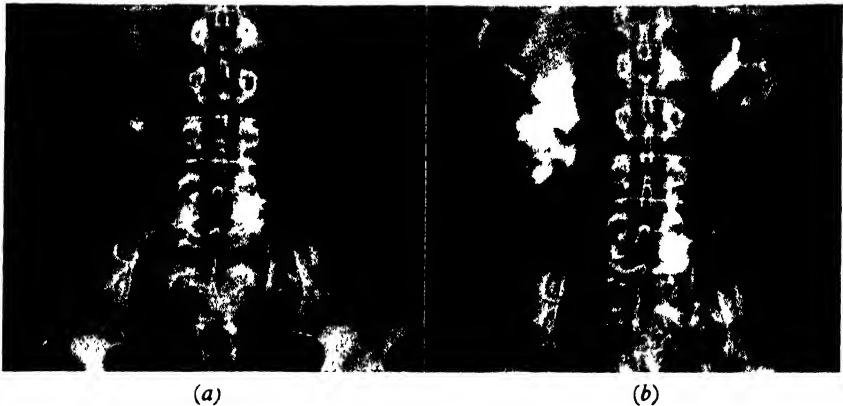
(a) Plain X-ray showing a renal calculus. In which part of the kidney is it situated? (b) Same case. Excretory pyelogram. The stone is in the pelvi-ureteric junction. Pyelolithotomy is indicated.
